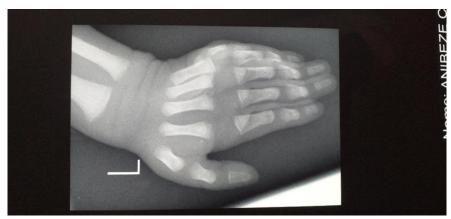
Showing xray of left with fully developed bone on six digit
